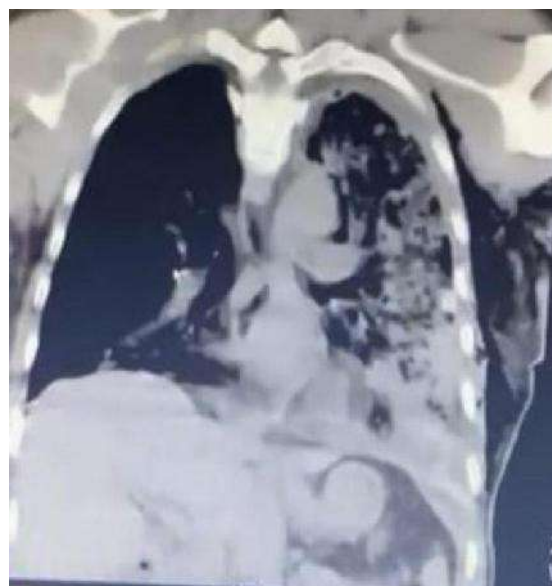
CT pulmonary angiogram in the coronal plane. A chest tube was installed in the left anterolateral 5-6th intracostal with a tip in the left pleural cavity.
